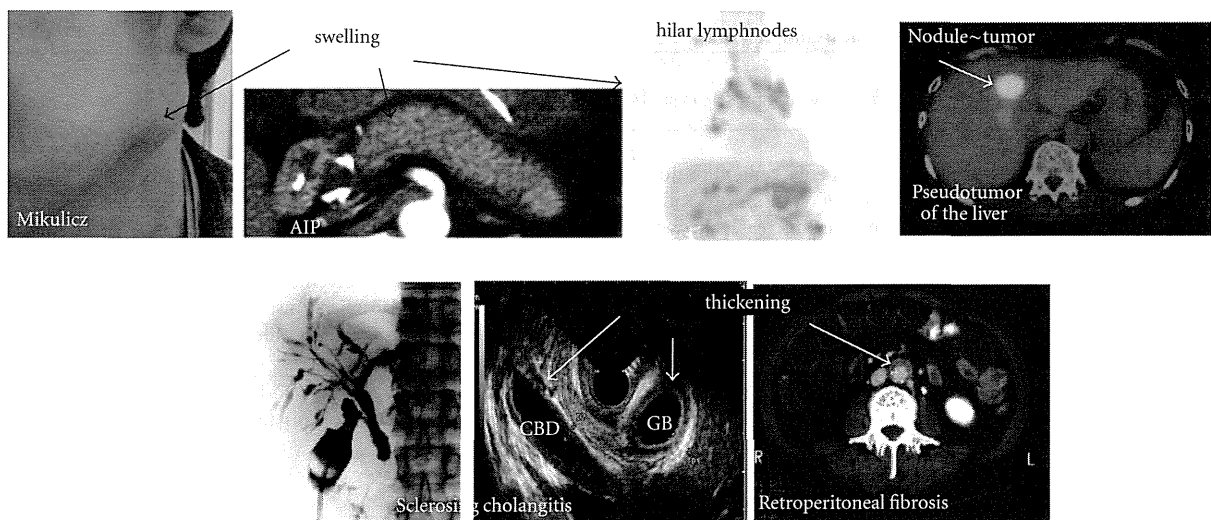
Clinical findings of IgG4-related disease. Physical examinations and imaging on US/CT/MRI can show the characteristic diffuse/localized swelling, masses, or thickness in single or multiple organs.
